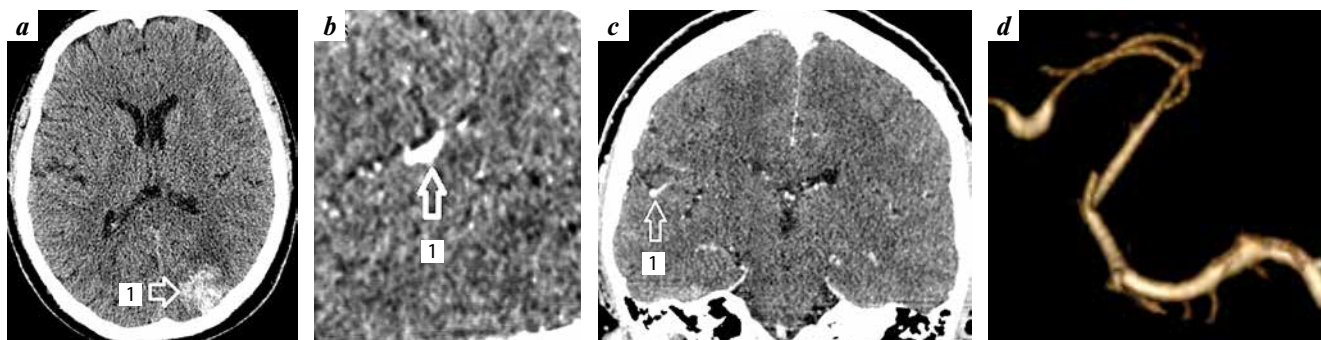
Spiral computed tomography (CT) and spiral computed tomography angiography (SCTA) of the brain: a) CT-signs of hemorrhage (1) in the projection of cavernous angioma of left occipital lobe; b, c) fusiform expansion of cortical segment of posterior parietal branch of the right medial cerebral artery in sagittal and frontal planes of multiplanar reconstruction; d) three-dimensional CT-reconstruction of the affected artery segment with fusiform aneurysm
